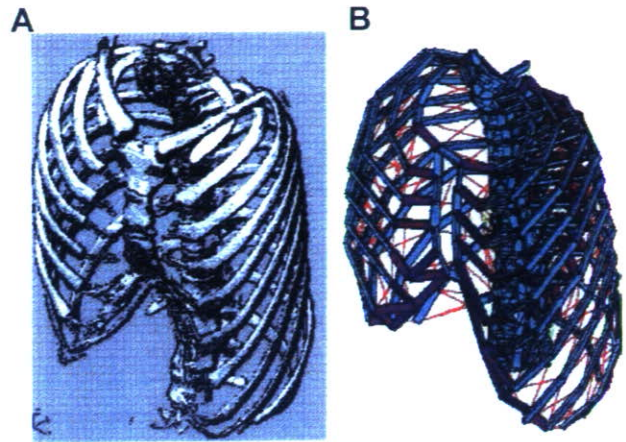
Based on the 3-dimensional computed tomographic data, we produced a computer-assisted design model for each patient. A, Three-dimensional computed tomographic image of a patient. B, Corresponding computer-assisted design model.
